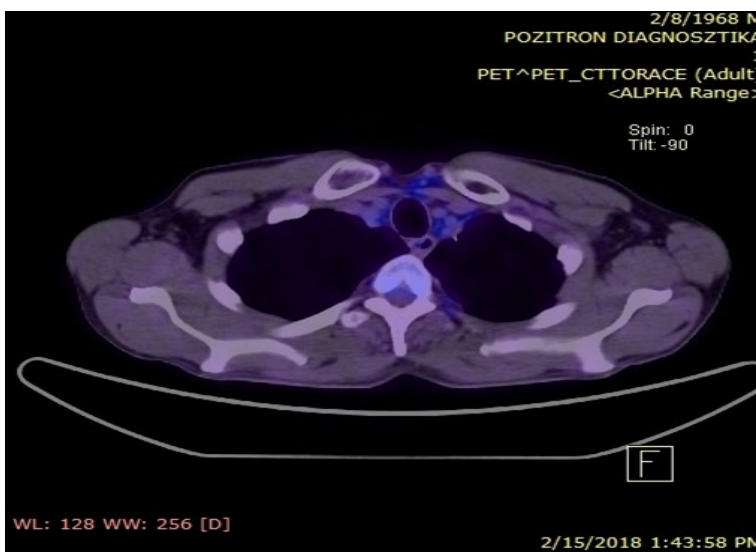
PET-CT (15.02.2018): Complete Response
